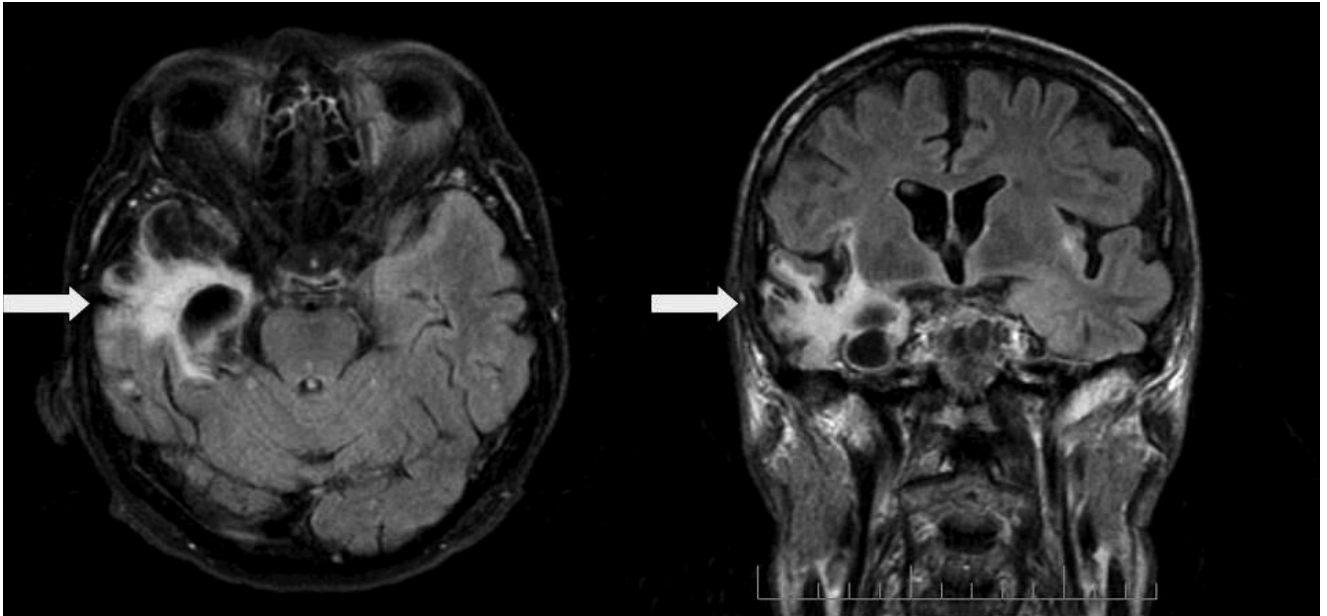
Brain MRI, FLAIR sequence – significant local atrophy of the right temporal lobe with cystic degeneration
